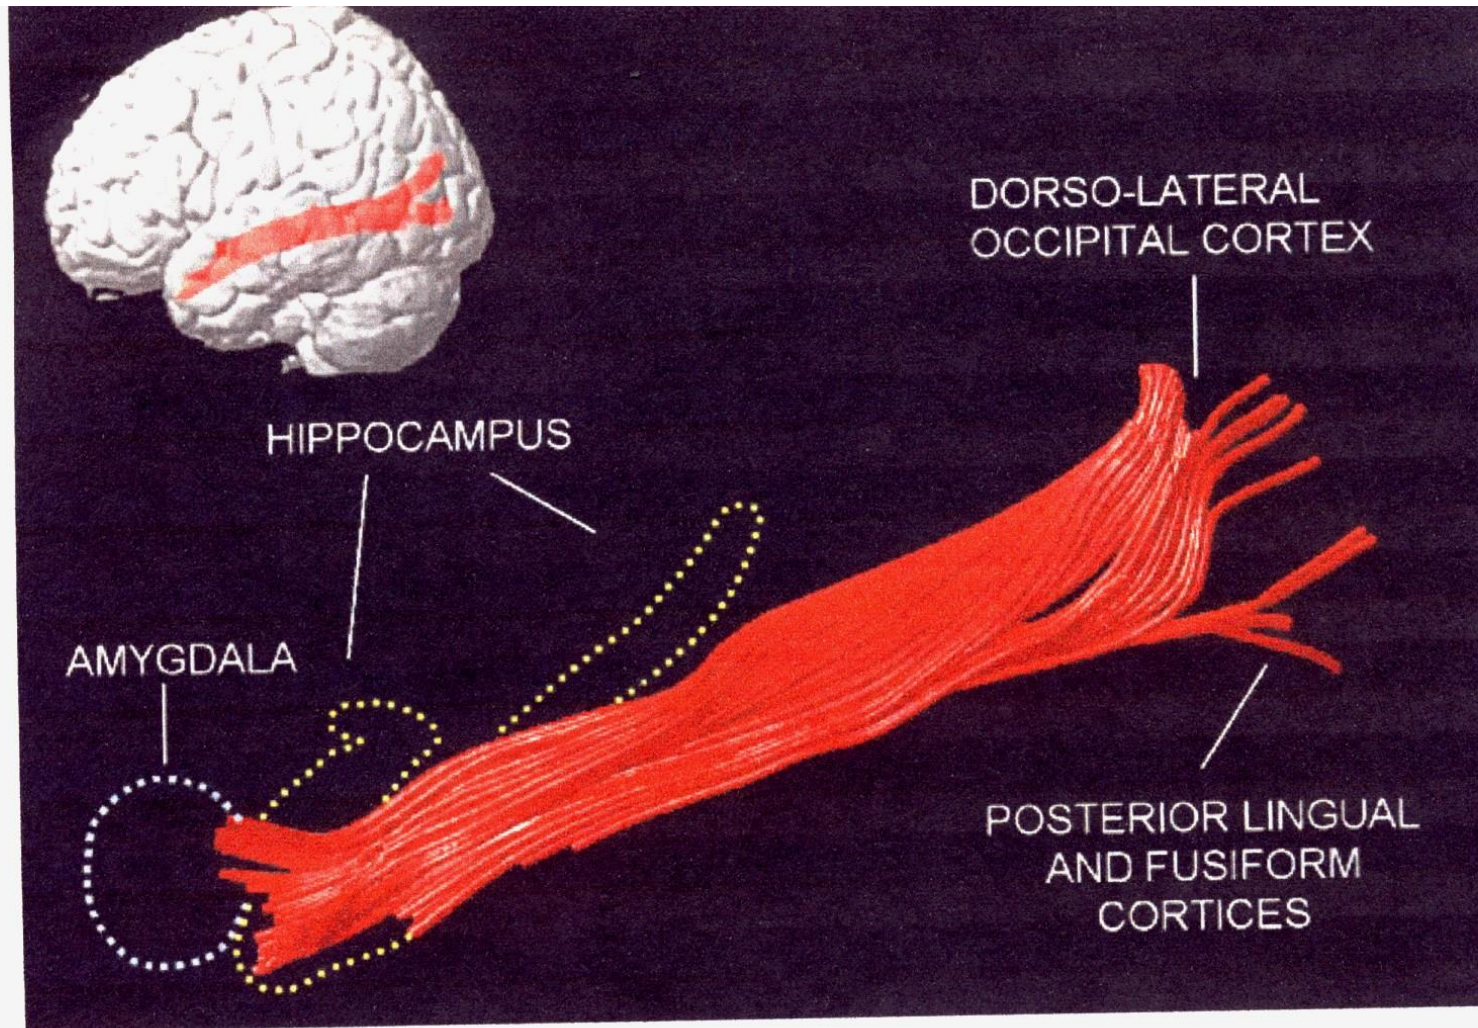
Reconstruction of the ILF in the average DT-MRI data set. The long fibres originate from extrastriate areas of the occipital lobe and terminate in lateral temporal cortex and medial temporal cortex in the region of the amygdala and parahippocampal gyrus.
